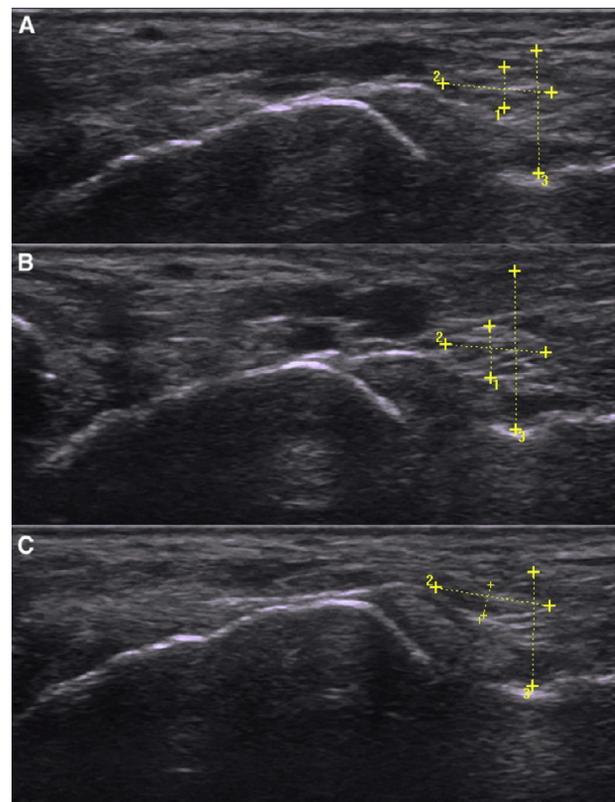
Ultrasound measurements of the tarsal tunnel and tibial nerve. (A) Anatomical position of the ankle. (B) Plantarflexion. (C) Dorsiflexion. Line 1, anterior-posterior distance of the tibial nerve. Line 2, transverse distance of the tibial nerve. Line 3, anterior-posterior distance of the tarsal tunnel.
